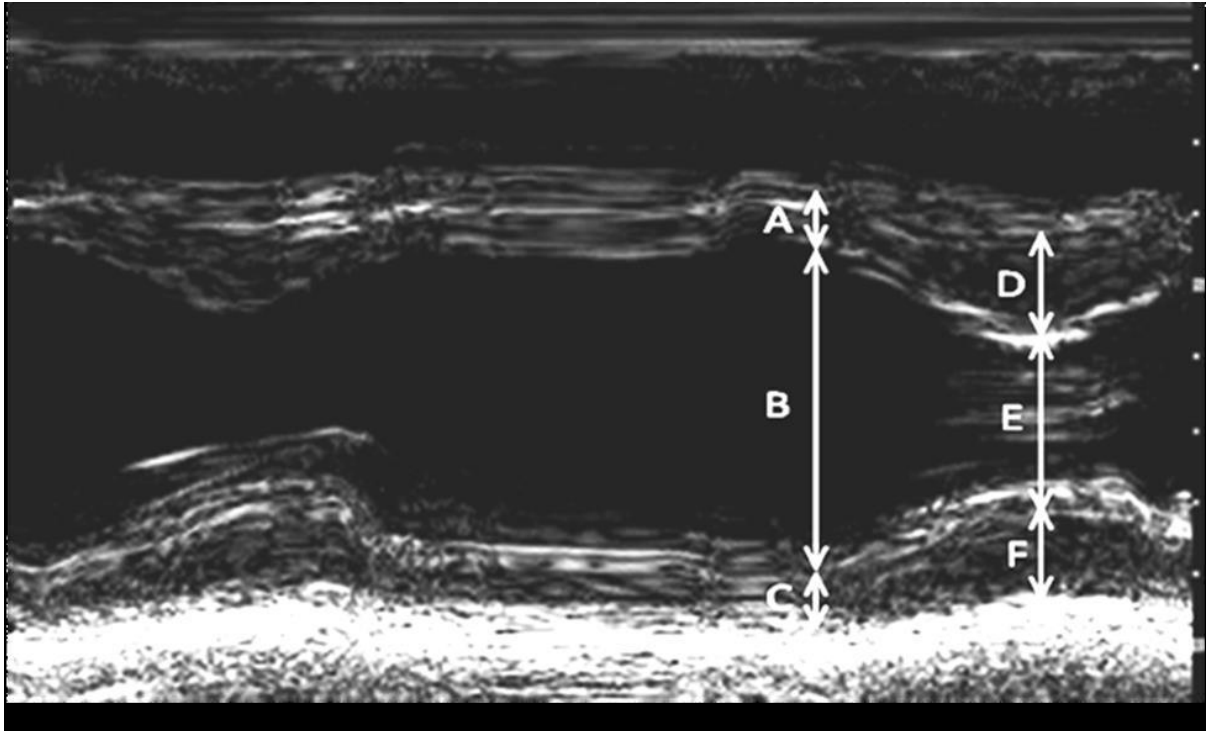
Example of an M-mode echocardiographic image obtained in the parasternal long-axis of the heart. M-mode images were used to determine left ventricular end diastolic internal diameter and septal and posterior wall thickness dimensions.
